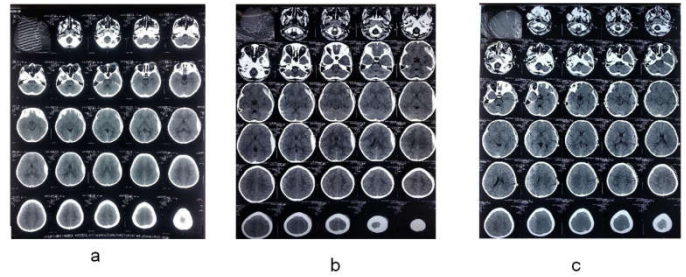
Figure vi (Patient 6): Hematoma size increase. Surgical evacuation was done. (a) CT head on admission (b) CT head on 3rd post admission day (c) CT head 2nd Post-operative day.
